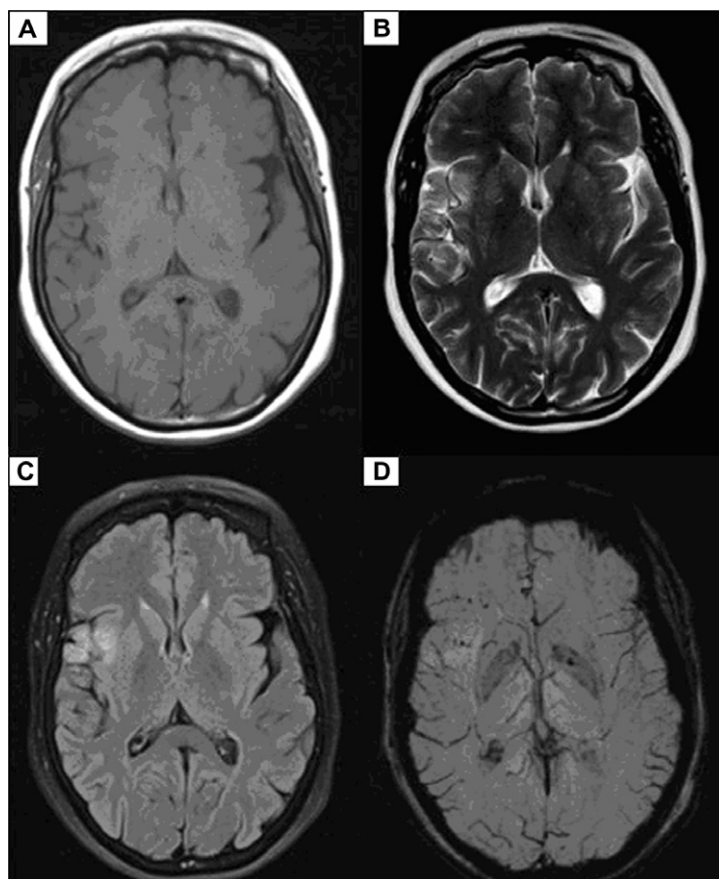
Sixty-three year old female patient presenting with left lag. Conventional T1 (A), FLAIR (B) and DWI (C) revealed infarct involving the right insular cortex. SWI minIP (D) images reveal foci of hemorrhagic transformation within the infarct.
